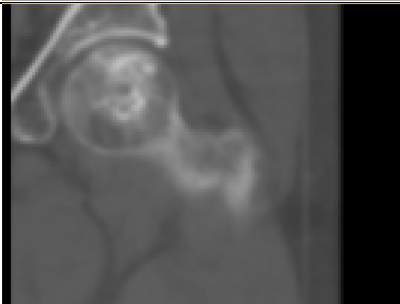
Typical example of a CT image of a femoral head with pre-collapse AVN. This image corresponds to the MR image shown in Figure 6. The high intensity regions indicate areas of increased density but this does not relate to the boundary of the necrotic segment.
